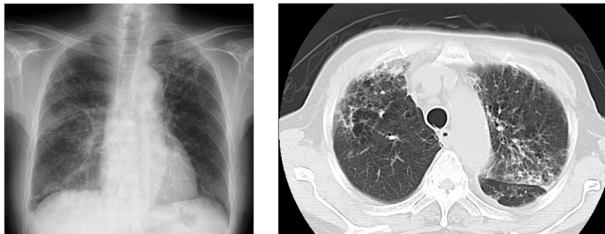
In 2015.11.5 Chest X-ray shows diffuse bilateral reticulonodular infiltration and chest CT scan shows multifocal ground glass and air-space opacities bilaterally.
